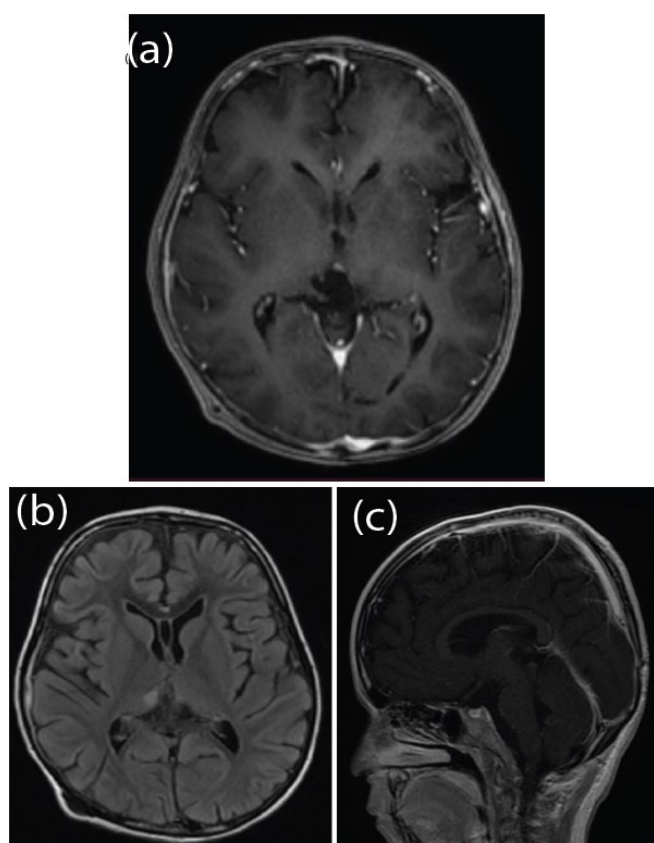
Eight Months Post Treatment MRI; (a) T1 Post-Contrast, (b) FLAIR, (c) Sagittal T1 Post-Contrast
